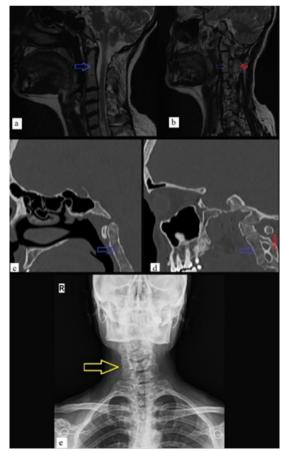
Sagittal slices of the cervical region in T2-weighted MR images (Blue arrow, fusion in the vertebral corpus (a, b); red arrow, fusion in the vertebral arch (b)). Sagittal slices in CT images (Blue arrow, fusion in the vertebral corpus (c, d); red arrow, fusion in the vertebral arch (d)). Direct anteroposterior radiographs (Yellow arrow, scoliosis (e)).
